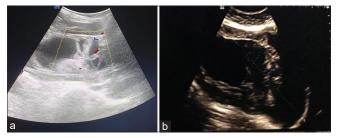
(a and b) score with ultrasound of ovary; (a) multiloculated solid-cystic ovarian mass with U score 4 – patient had ascites too, (b) large cystic space-occupying lesion with U score 1
